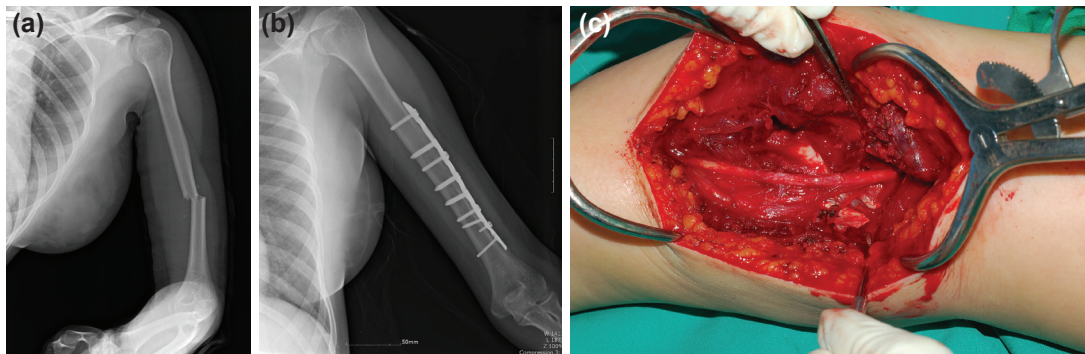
A 22-year-old injured in a motor vehicle accident with middle-distal transverse humeral shaft fracture. (a) Preoperative radiograph demonstrating displaced fracture on middle-distal humeral shaft. (b) Postoperative radiograph of patients who underwent open reduction and plate fixation. (c) Macroscopically intact radial nerve.
